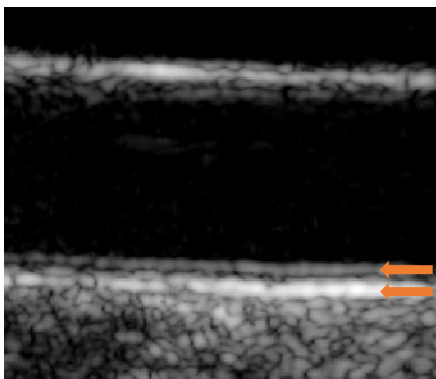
A typical ultrasound image of the common carotid artery. The echoes originating from the intima and adventitial layers of the arterial wall form a typical double-line pattern as indicated by the arrows. Notice the “wavy” appearance of these lines.
